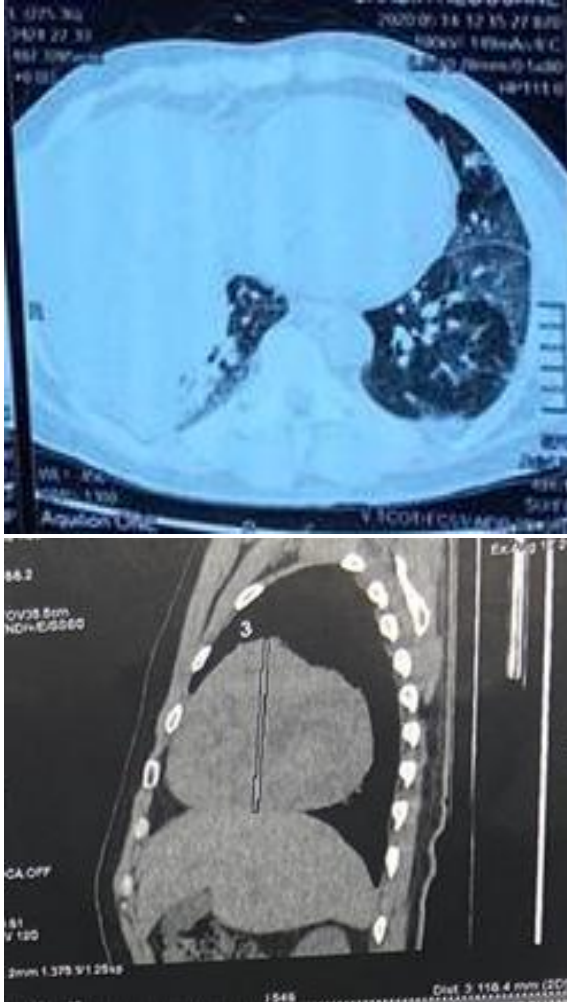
Thoracic computed tomographic scan showing a right thoracic mass with COVID pneumonia.
